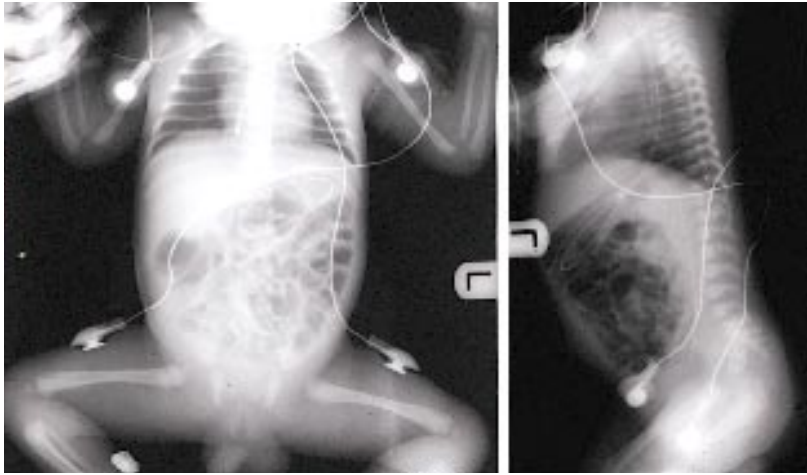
Anteroposterior and lateral radiographic views of a “free,” broken umbilical artery catheter lying in the abdominal and thoracic aorta. The catheter broke at the insertion site during planned removal. The remaining catheter had to be surgically removed.
